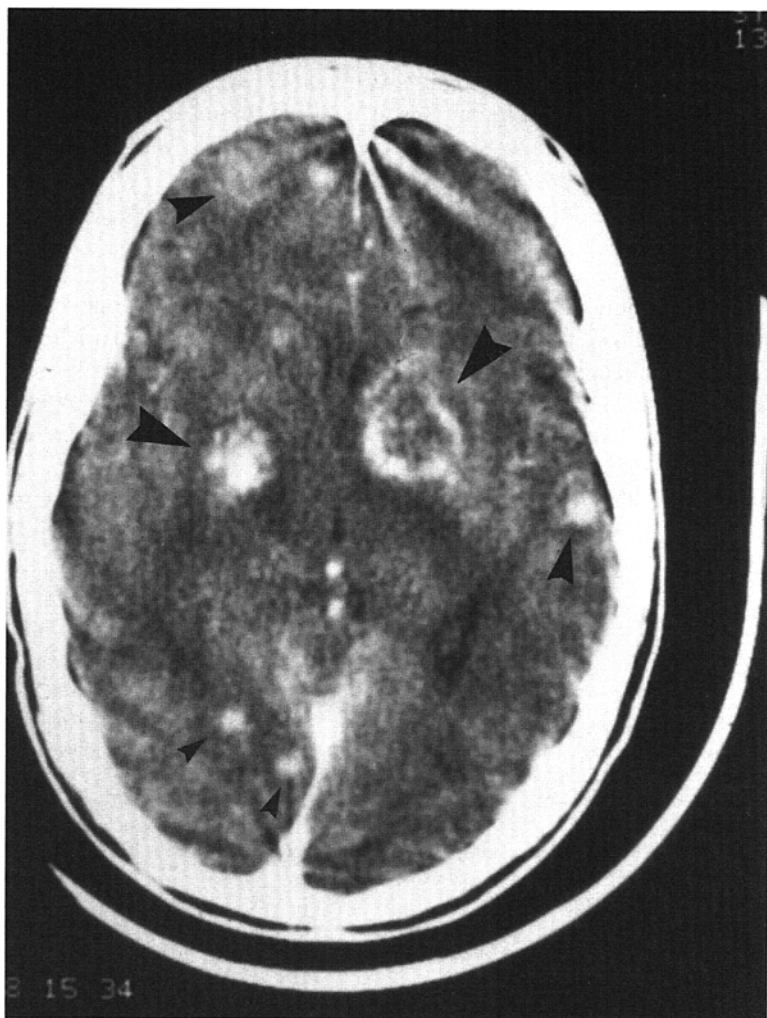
Computed tomography scan of a brain with toxoplasmic encephalitis reveals multiple round, ring-enhancing, nodular lesions in both hemispheres (arrows). The distribution and multiplicity of these lesions are typical of toxoplasmic encephalitis.
